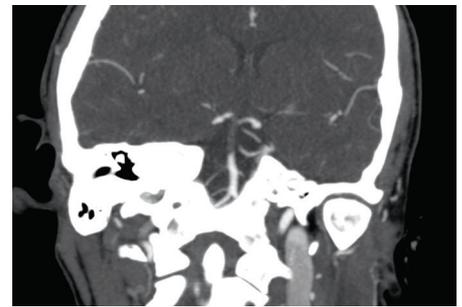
Coronal reconstruction of the CTA demonstrating an occlusion of the mid distal BA.
